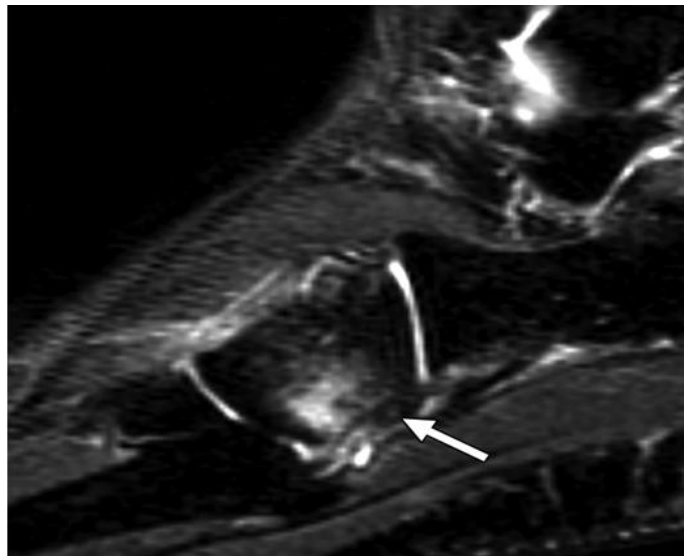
MRI STIR sequence sagittal section at level of lateral midfoot shows a linear hypointense signal perpendicular to cortex of cuboid on the proximal lateral aspect with surrounding bone marrow edema.
